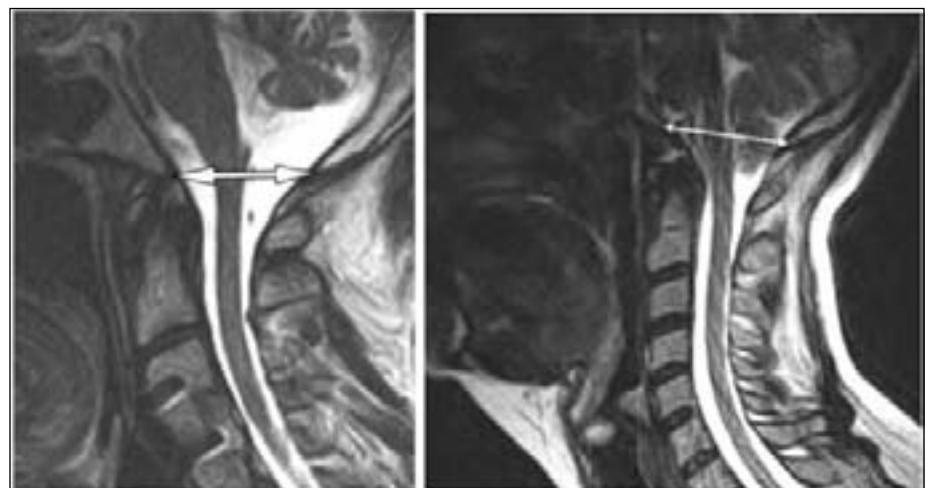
(left) MRI Depicting Normal Cerebellar Position⁽²⁾
